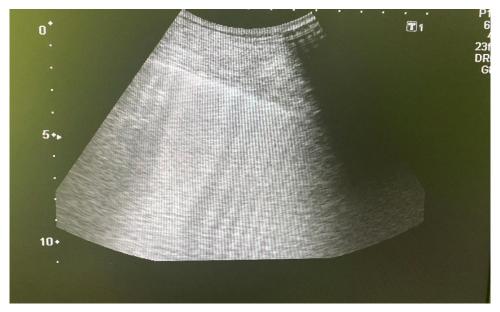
Sonogram with the effect of "white lung"
